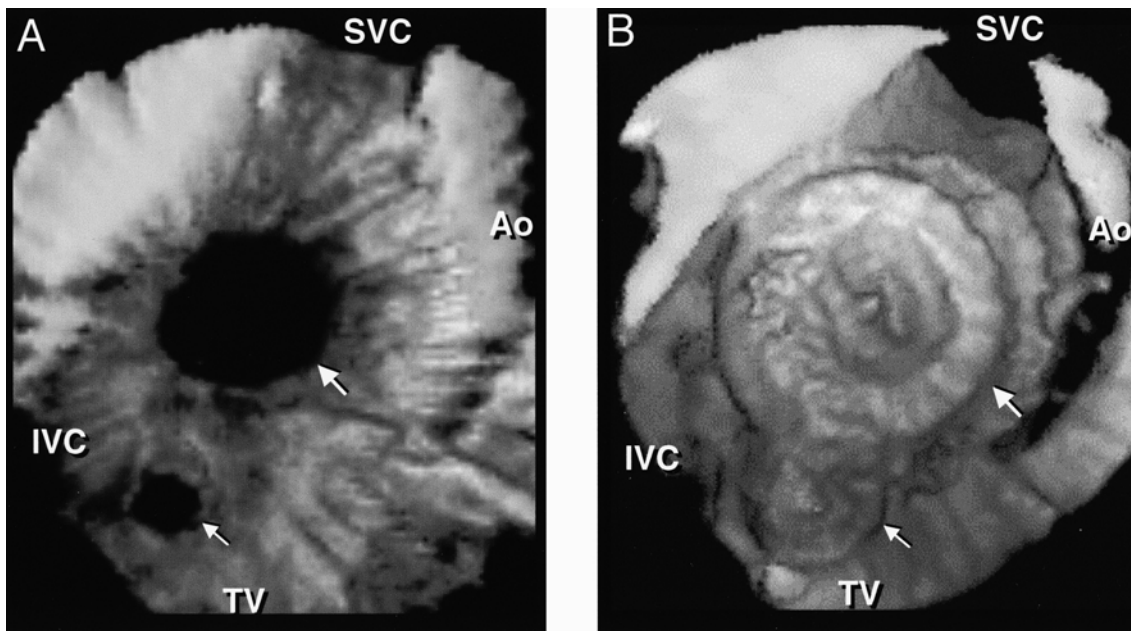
Three-dimensional transoesophageal echocardiography en face view for atrial septum from right atrial side (A and B). A, before devices were deployed demonstrating two defects with sufficient rim between (thick arrow denotes the larger defect, thin arrow denotes the smaller defect) with their surrounding structures. B, after devices were deployed demonstrating overlap between the devices (thick arrow denotes the larger device and thin arrow denotes the smaller device). Ao=aorta; IVC=inferior vena cava; SVC=superior vena cava; TV=tricuspid valve.
